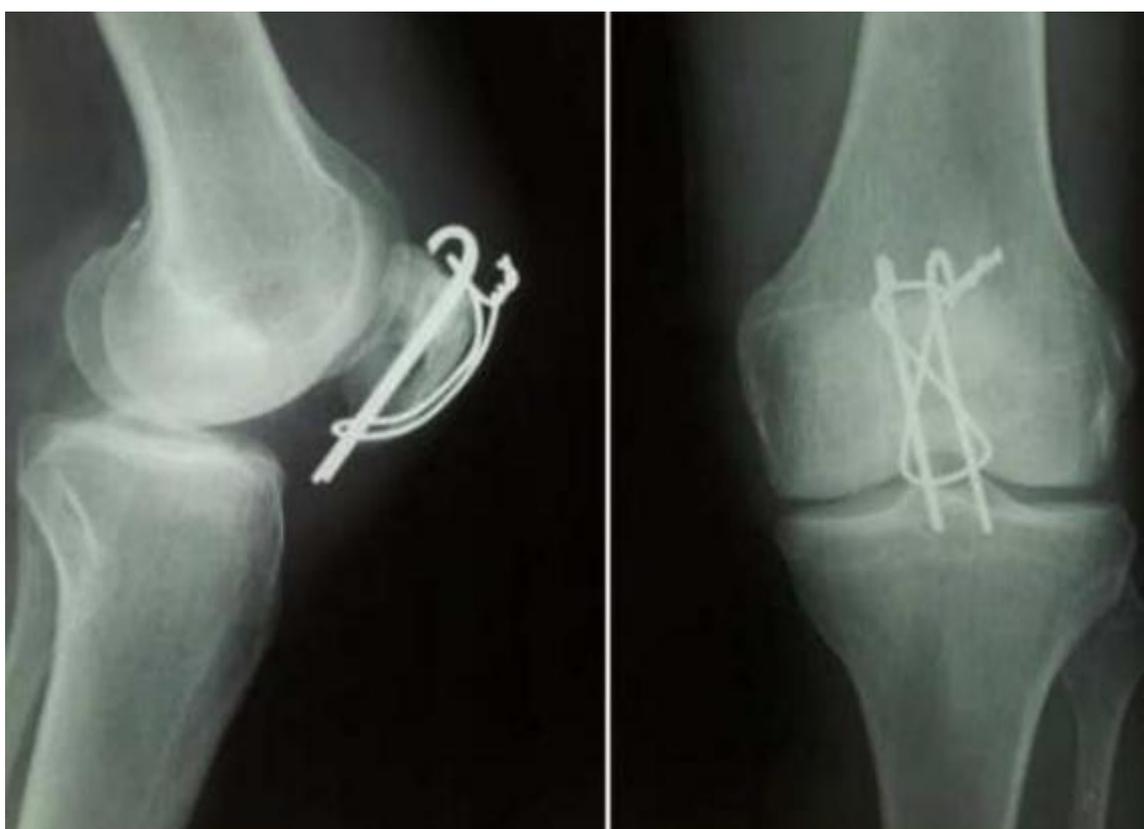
Knee X-ray : a patella fracture treated by tension band wirinig.
